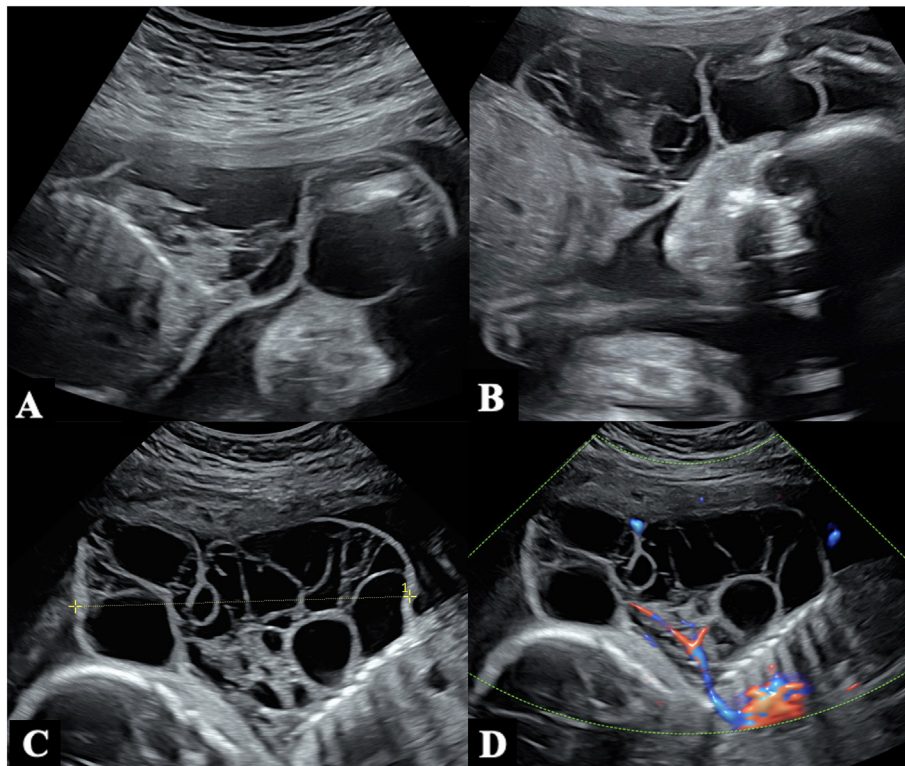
(A,B) US at 20 weeks showing a 5.45×3.72 cm nonvascular cystic structure in cross-sectional views in relation to fetus. (C,D) US at 24 weeks showing a $10.6 \times 6.1 \times 10.2$ cm mass with evidence of a vascular supply with color-flow Doppler and septa arising from the left axilla, anterior chest wall, and inferior left arm up to the elbow.
